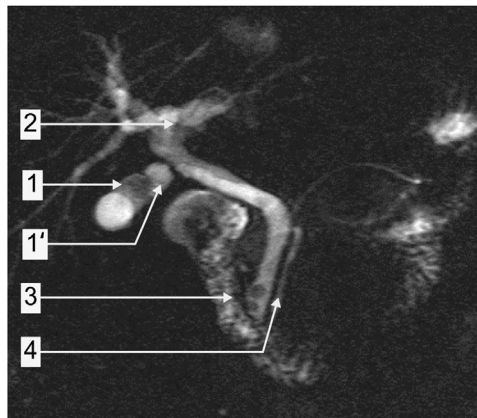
MRCP: MRI visualization of the hepatobiliary-pancreatic duct system: liquid-filled spaces appear as light structures: 1, gallbladder with gallstone (1'); 2, intrahepatic bile duct; 3, duodenum; 4, Pancreatic duct. *Courtesy: Dr. A. Fingerle, Klinikum rechts der Isar.*
